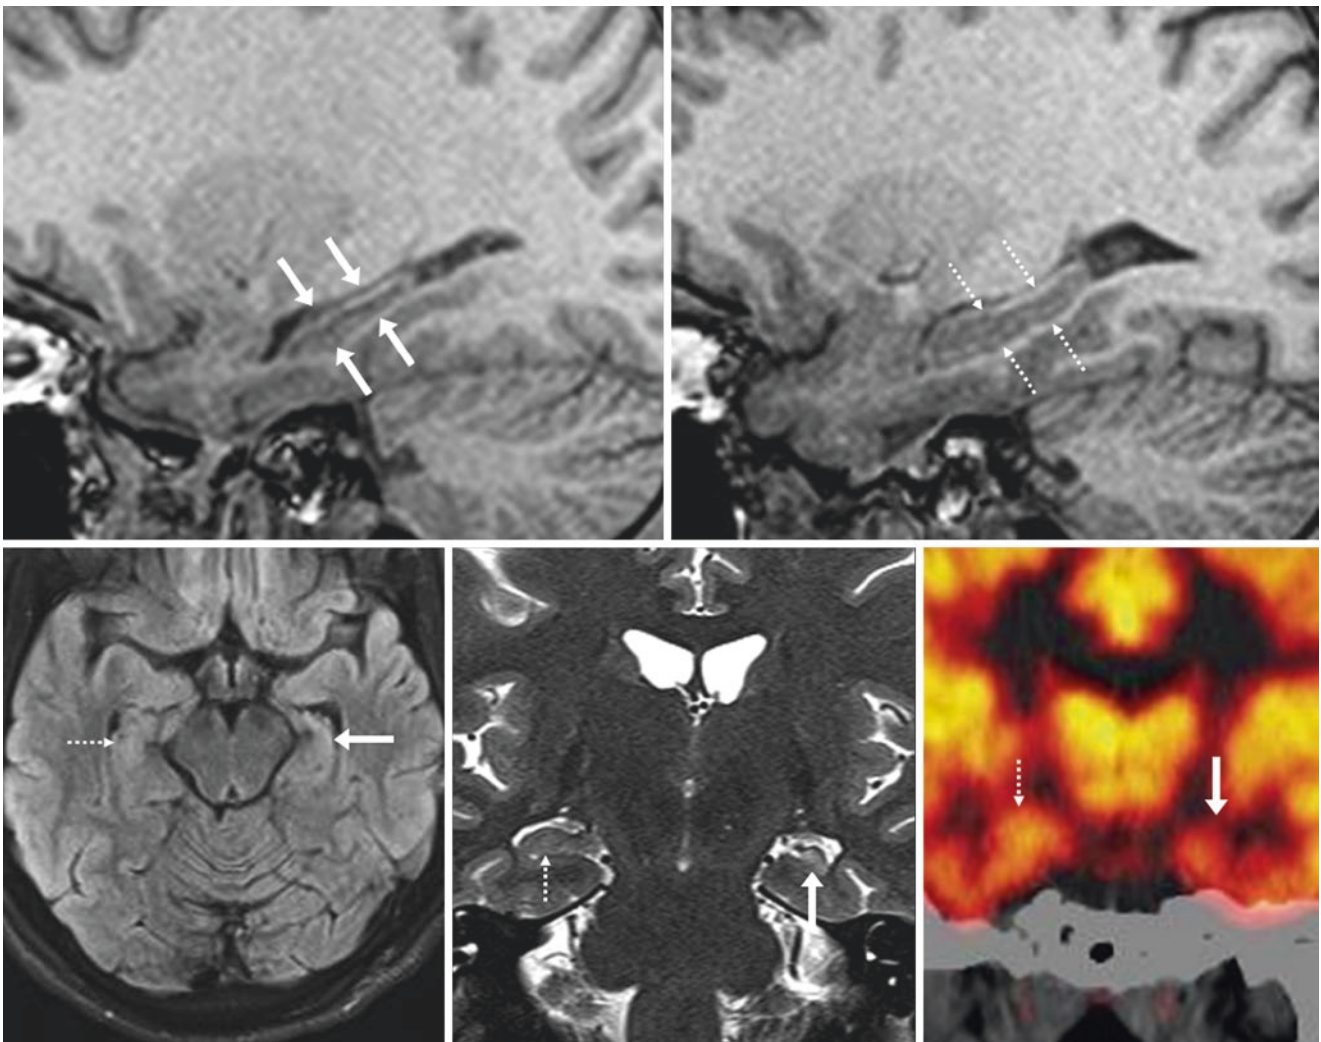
Comparison case of mesial temporal sclerosis (MTS). A 22 year old with seizures had left hippocampal MTS-atrophy (between arrows) when comparing sagittal T1WIs of the left (top left) and right (top right) sides and was also seen on axial FLAIR (bottom left) and coronal T2WI (bottom middle). Dotted arrows outline the normal right hippocampus, which has mild normal corrugation. ¹⁸F-FDG-PET (bottom right) confirms decreased left medial temporal uptake
